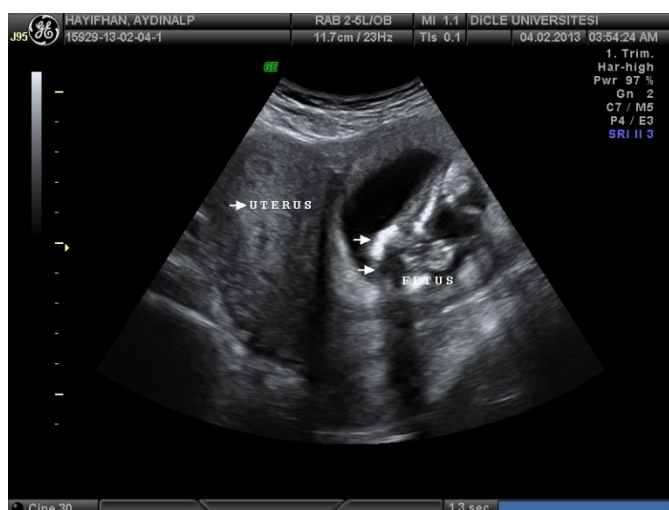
Ultrasonographic presentation of the first case
